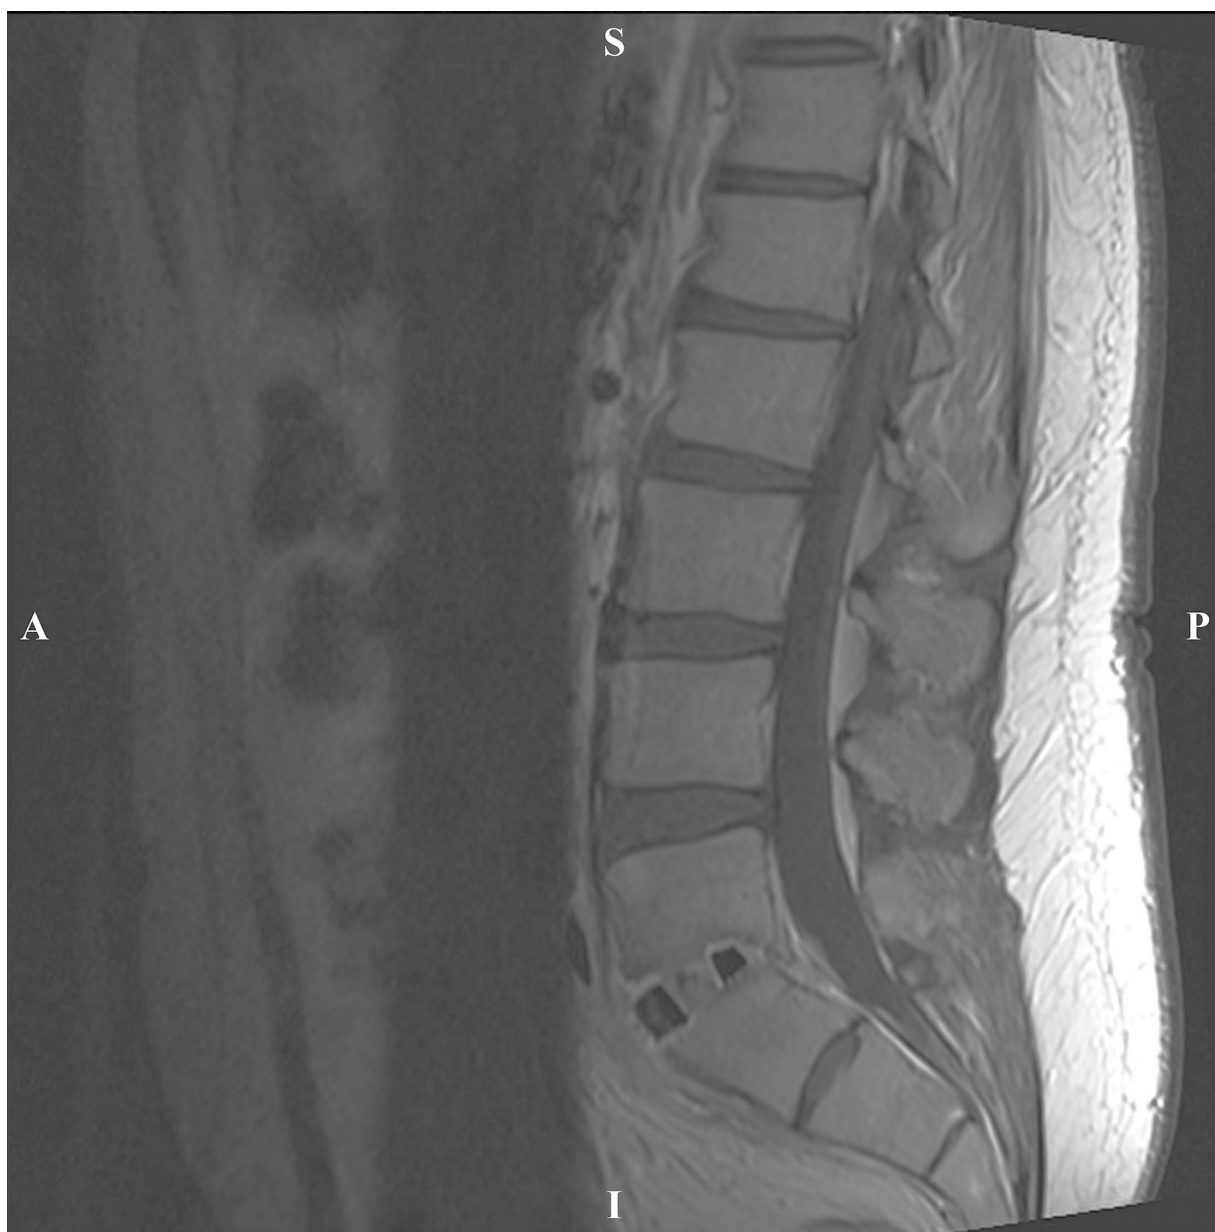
Case 2: Contrasted MRI performed 15 months post-op showed good positioning of the Si_3N_4 interbody spacer, successful arthrodesis, and no recurrence of the infection.
